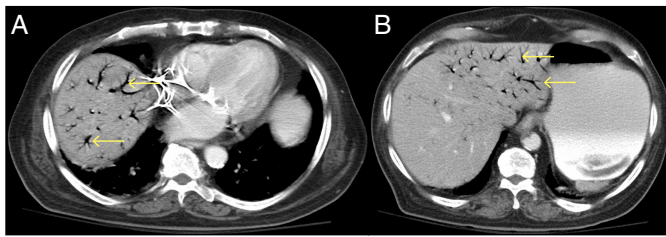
Abdominal CT showing (A) air within the branches of hepatic vein (arrows) and (B) air in the hepatic venous system extended within 2 cm of the liver capsule (arrows).
